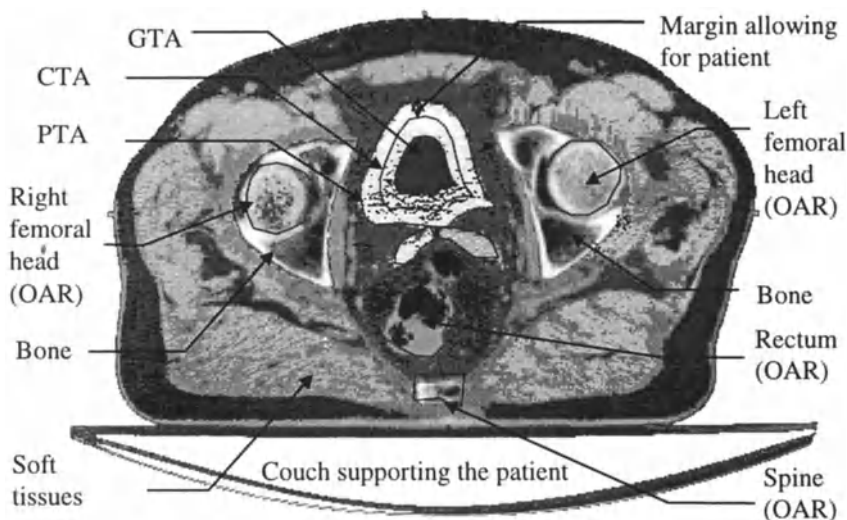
CT slice of a pelvic region with manual delineation of the bones, the organs at risk, the target (allowing for marginal spread and patient movement)
